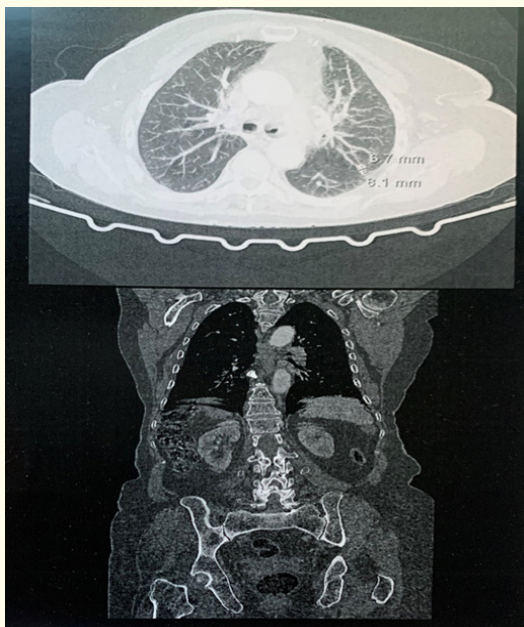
Full -body Computed Tomography (CT) showing absence of secondary lesion.
